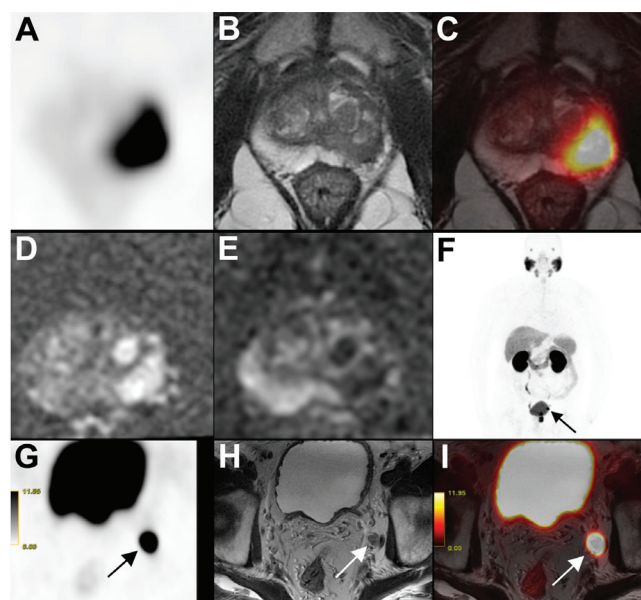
Eighty-three-year-old patient with Gleason score 4+4 prostate cancer detected by prostate 12-core needle biopsy with serum prostate specific antigen level of 5.8 ng/mL at the time of diagnosis. Axial Ga-68 prostate specific membrane antigen (PSMA) positron emission tomography (PET) (A), axial T2-weighted (T2W) magnetic resonance imaging (MRI) (B), fused PET/MRI (C), FOCUS diffusion weighted imaging for b=1400 s/mm² (D) and apparent diffusion coefficient (ADC) map for b=800 s/mm² (E) images showed intense PSMA uptake at the prostate tumor located at left peripheral zone (SUV_{max}: 53.9, SUV_{mean}: 37.0, ADC: 0.84 s/mm² for region of interest (ROI)-1 and SUV_{max}: 32.2, SUV_{mean}: 26.0, ADC: 1.04 s/mm² for ROI-2). Metastatic pelvic lymph node with intense PSMA uptake can be seen on maximum intensity projection (F) image, axial PSMA PET (G), axial T2W MRI (H) and fused PET/MRI (I) images (arrows)
